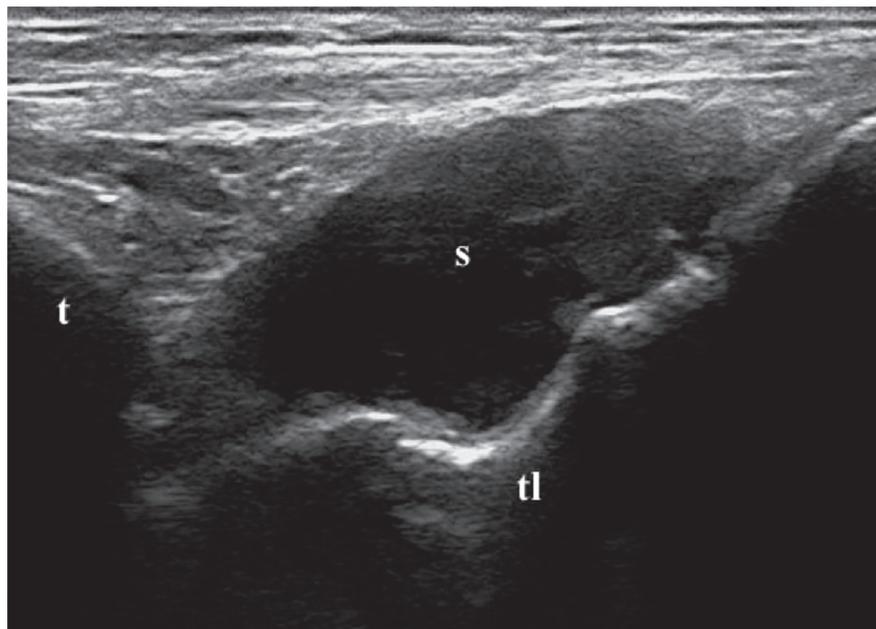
Longitudinal ultrasound image of tibiotalar B-mode synovitis (dorsal aspect) that shows abnormal hypoechoic intra-articular material (s). t: tibia; tl: talus.
